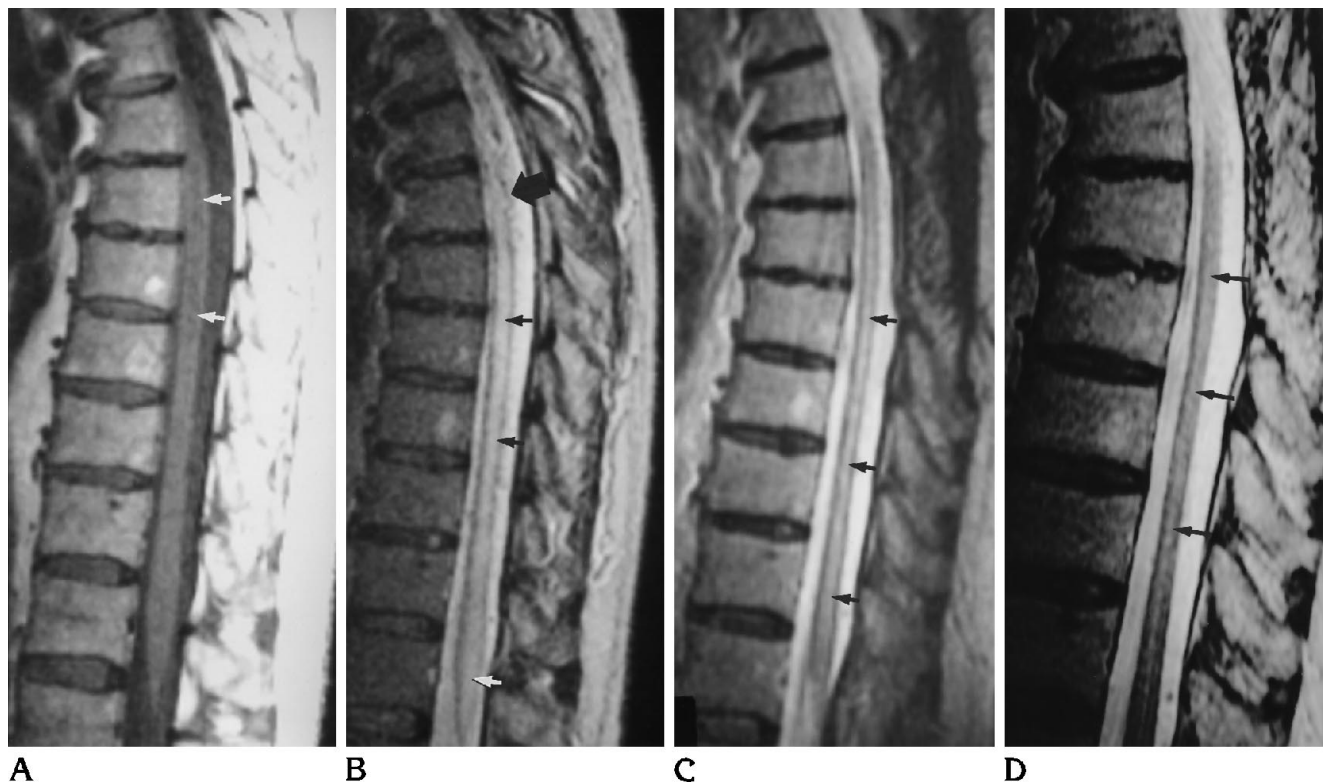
Case 4. A, T1-weighted sagittal thoracolumbar MR shows a subtle hypointensity within the midthoracic cord (*arrows*). B, T2-weighted MR show a dilated flow void (*thick arrow*), indistinct cord margins, and a diffuse hyperintensity within the cord extending up from the conus (*small arrows*). C, Posttreatment (9 months) T2-weighted MR shows that the cord is smaller with more distinct margins. However, the hyperintensity persists (*arrows*). D, At 34 months after treatment, T2-weighted MR shows less intramedullary hyperintensity (*arrows*).
